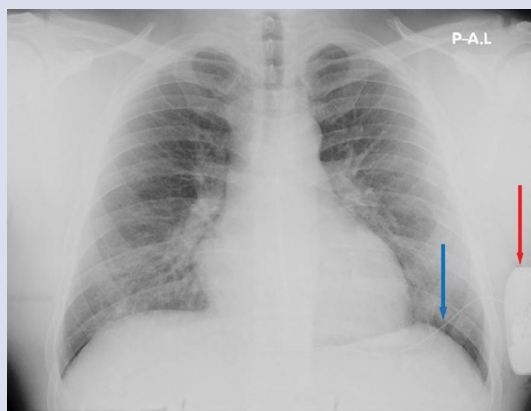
Chest radiograph showing proper position of device in the left lower half of the chest (red arrow) and its electrodes (blue arrow)
